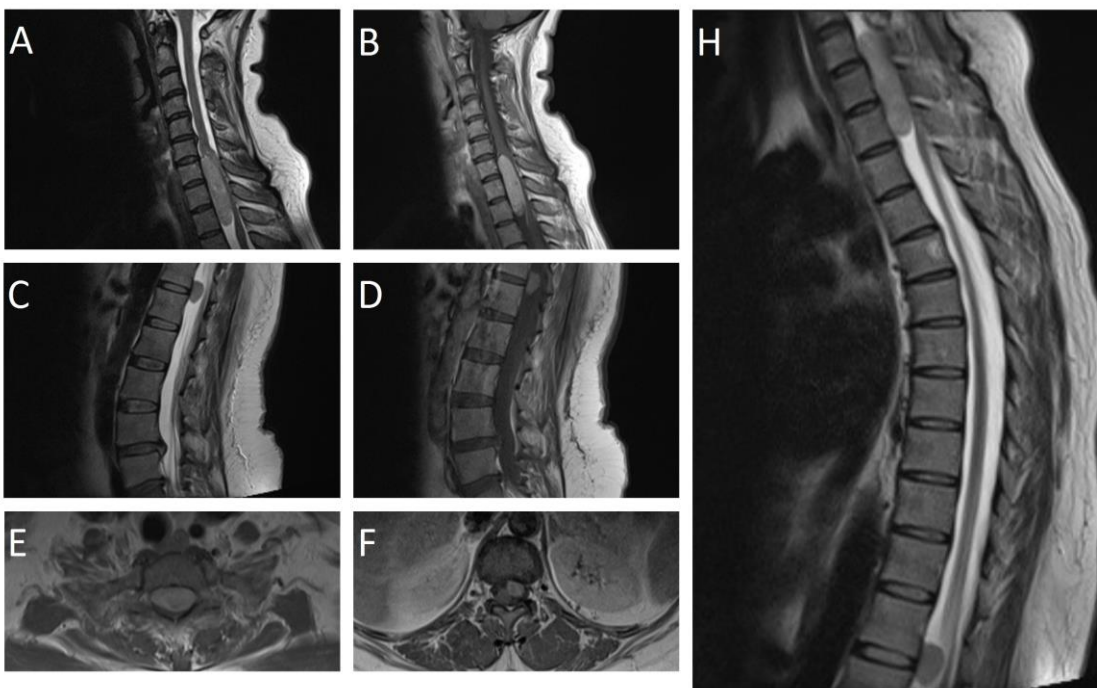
T2-weighted and contrast enhanced T1-weighted sagittal and axial MRI scans showed two intradural extramedullary spinal meningiomas located anterior to the spinal cord at C7-T2 (A, B, E and H) and T12 – L1 (C, D, F and H) levels displacing the spinal cord posteriorly at both levels.
